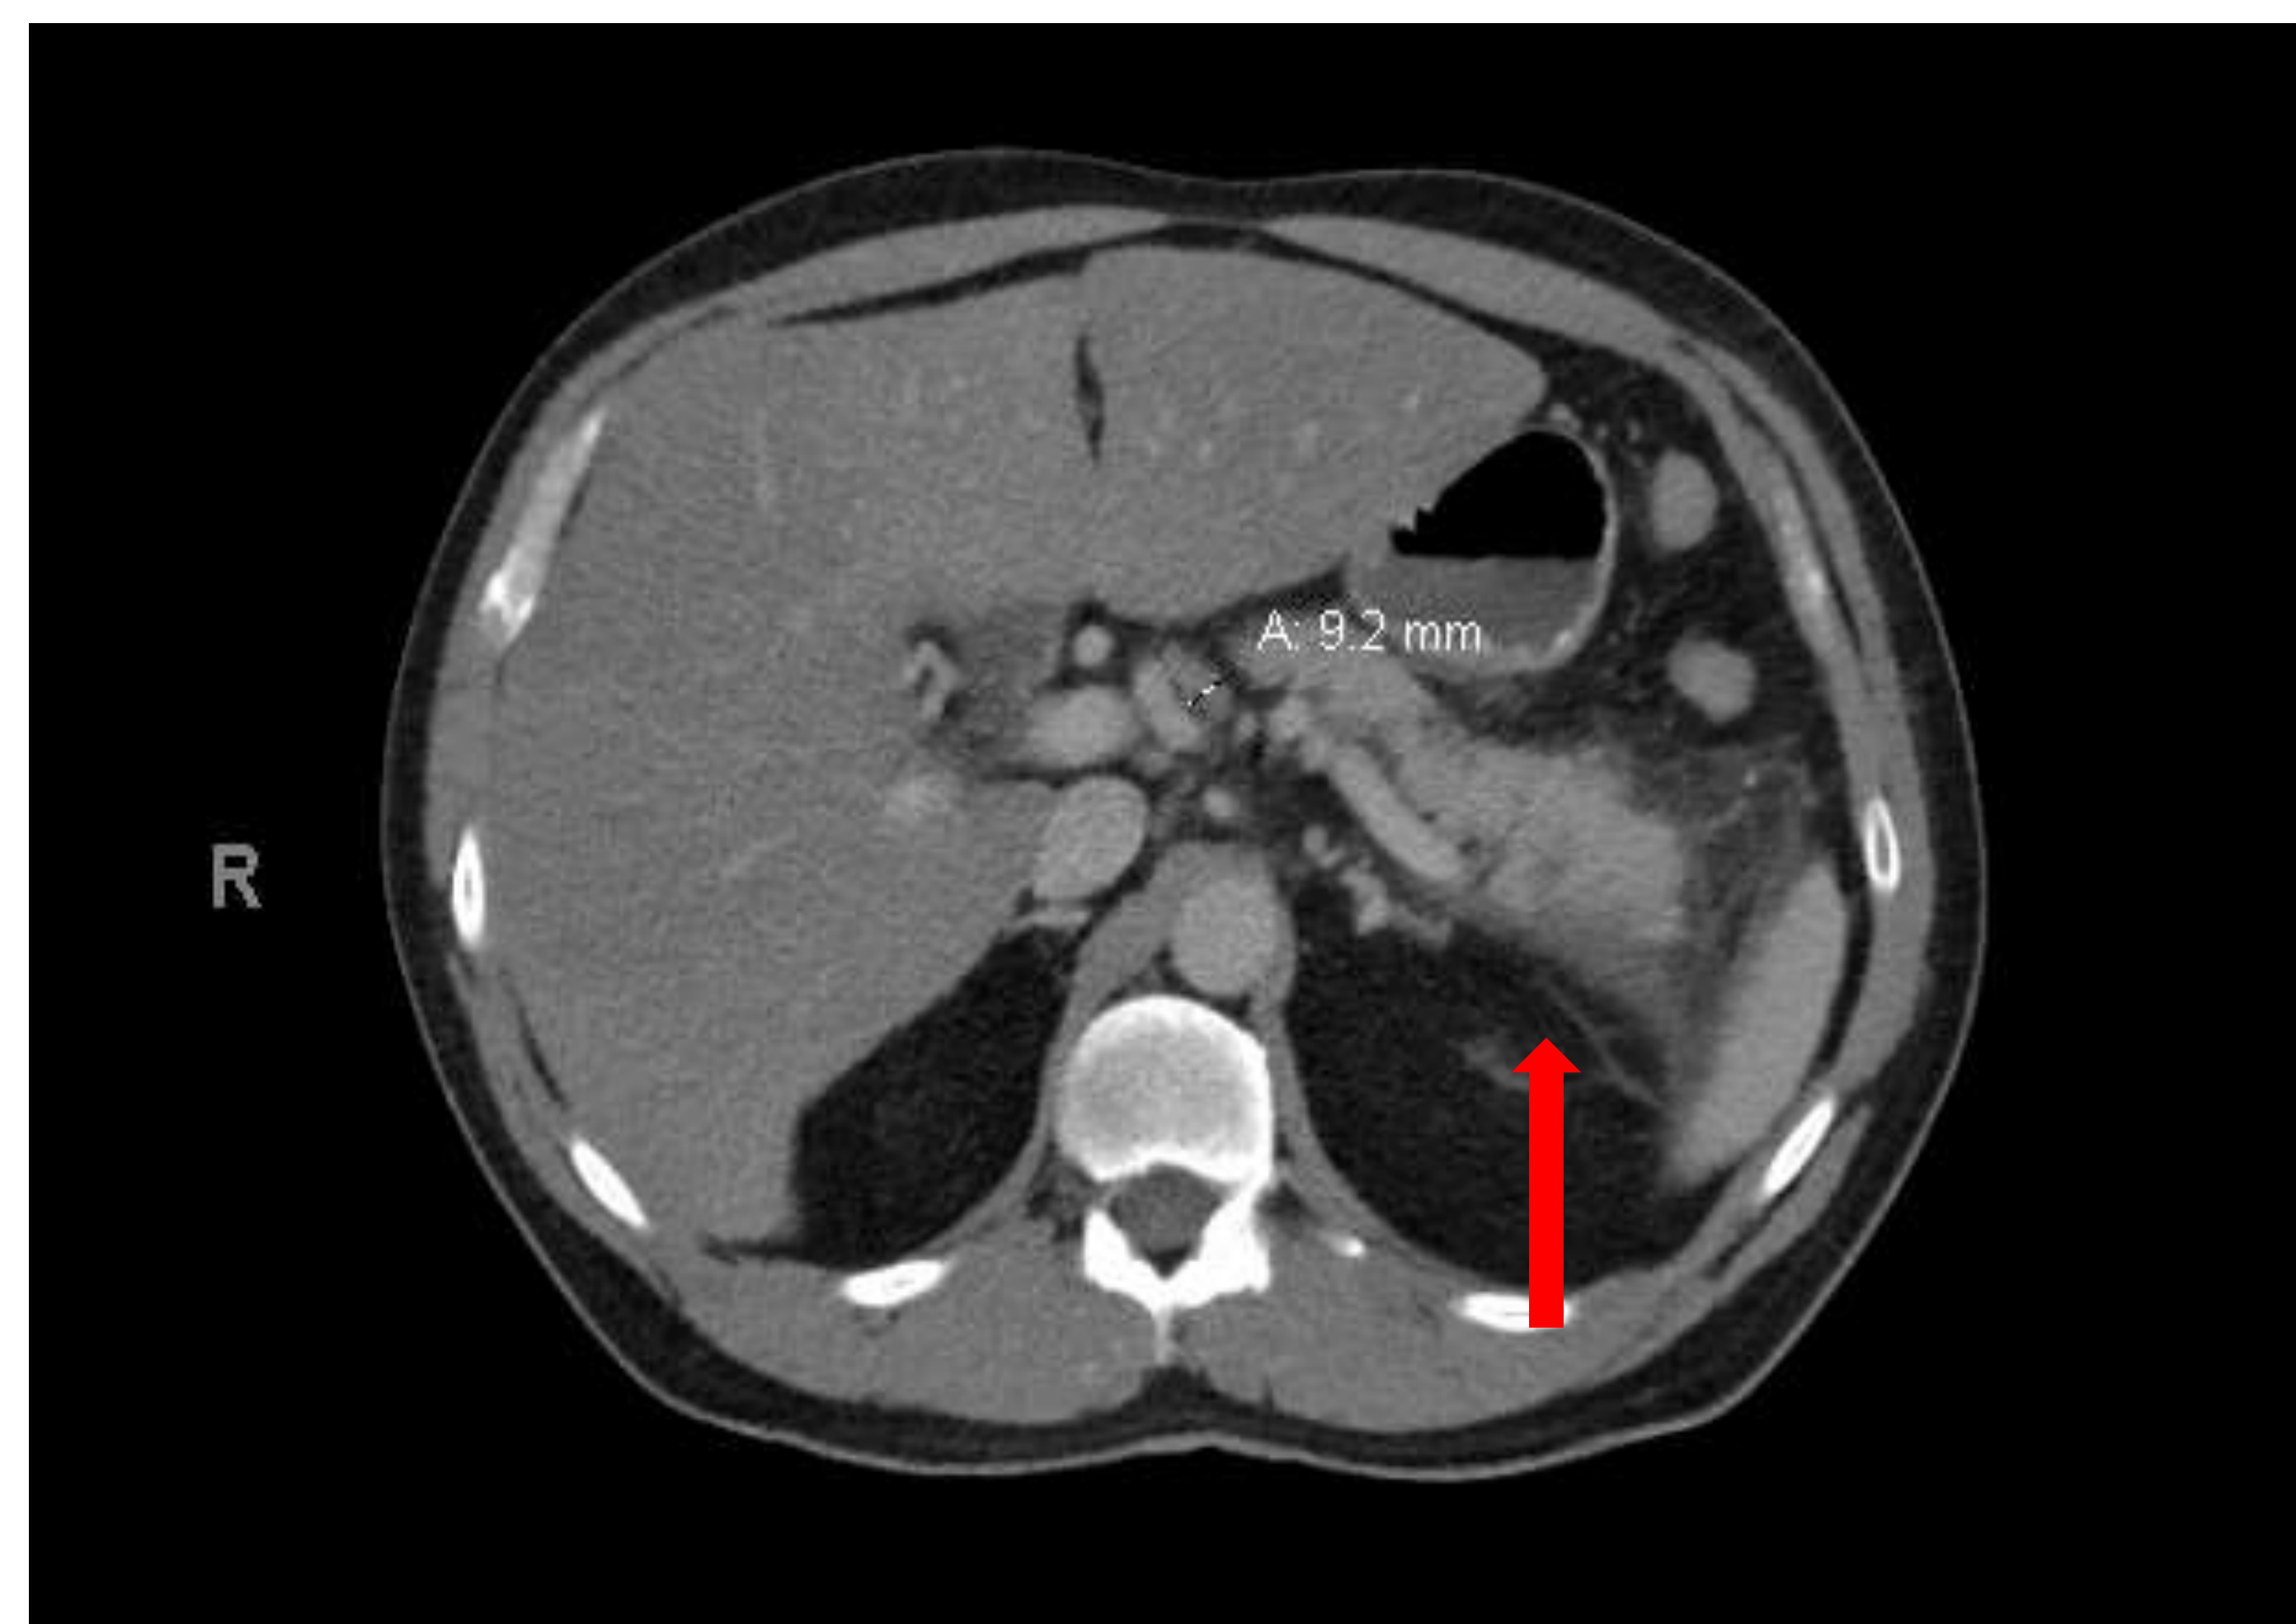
CT abdomen and pelvis demonstrating peri-pancreatic fluid and fat stranding (arrow), which is suggestive of acute pancreatitis.
